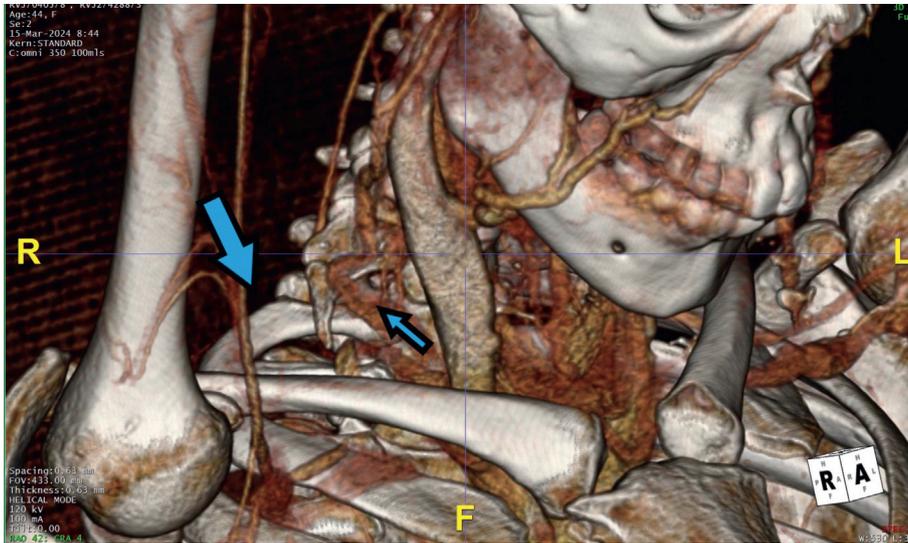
CT angiogram with 3D reconstruction showing a subclavian artery aneurysm secondary to a cervical band.
